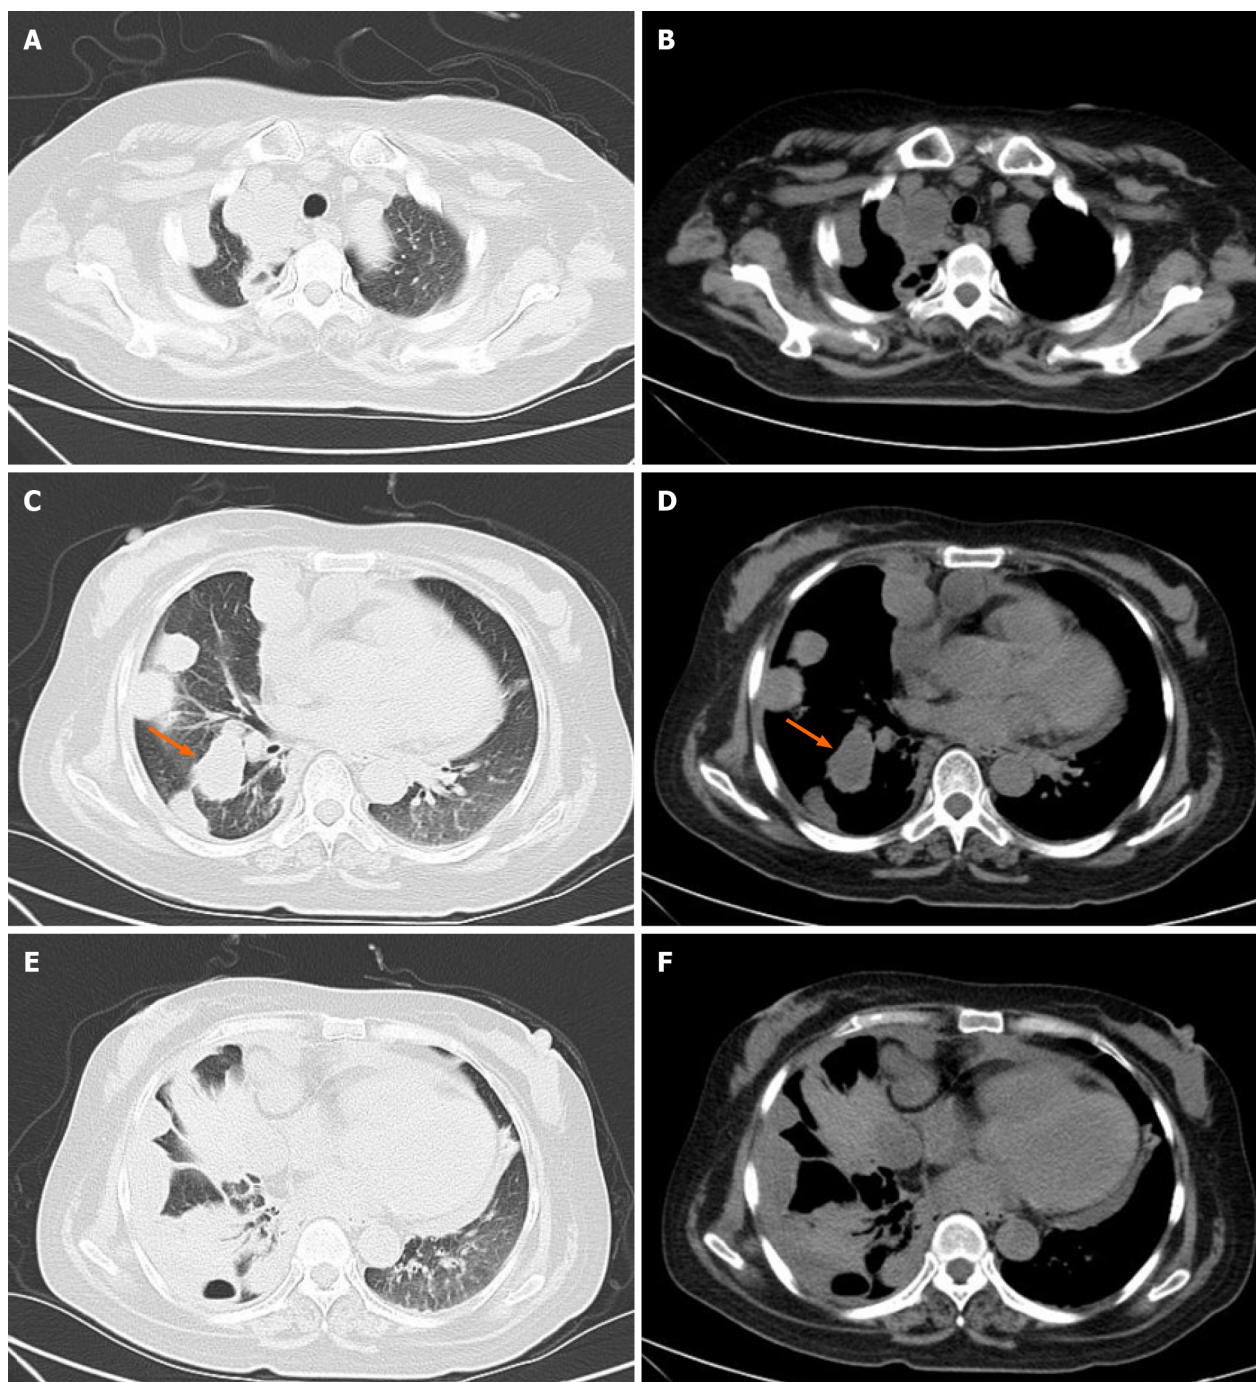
Axial computed tomography showed many nodular or hillock lesions in the right pleura, mediastinum, and interlobar fissure areas. A and B: At the upper level of the lung, the lesions were located in the right pleural and mediastinum areas; C and D: At the middle level of the lung, the lesions were located in the right pleura, mediastinum, and interlobar fissure areas (arrow); E and F: At the lower level of the lung, the lesions were located in the right pleura and mediastinum areas with atelectasis of adjacent lung.
